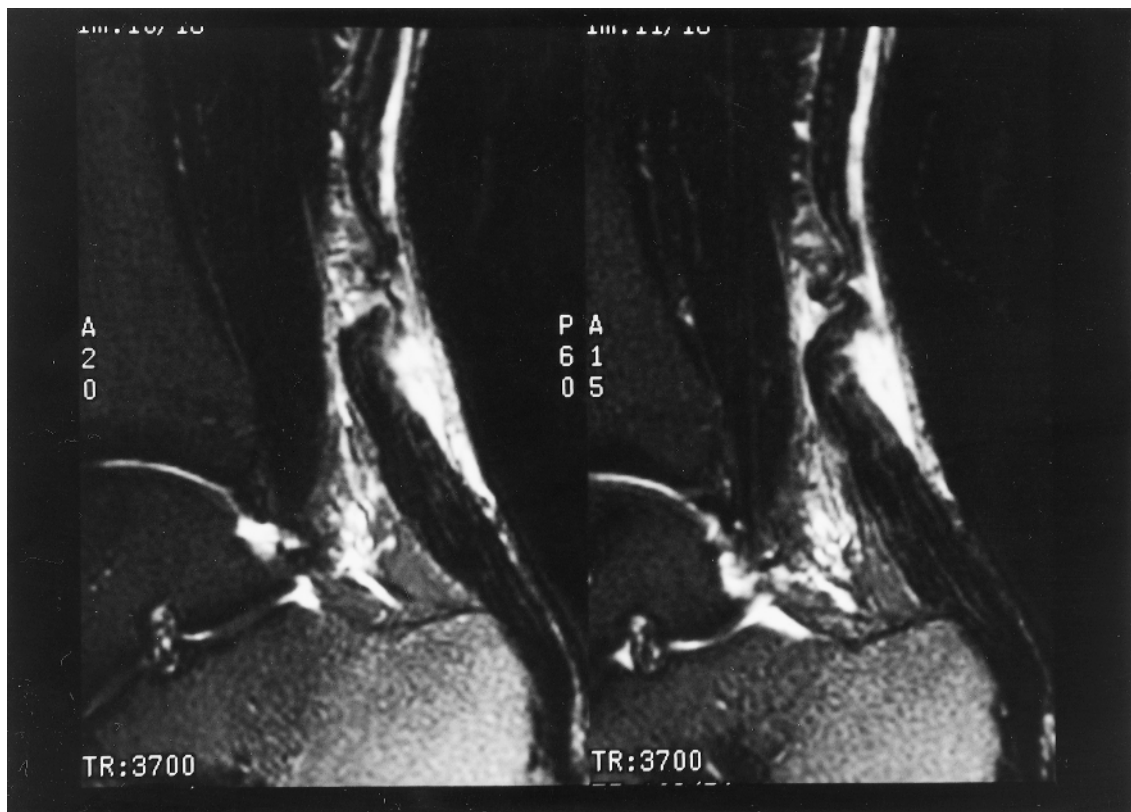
Achilles rupture. Sagittal T2-weighted images demonstrate rupture of the Achilles tendon at the musculotendinous junction.
